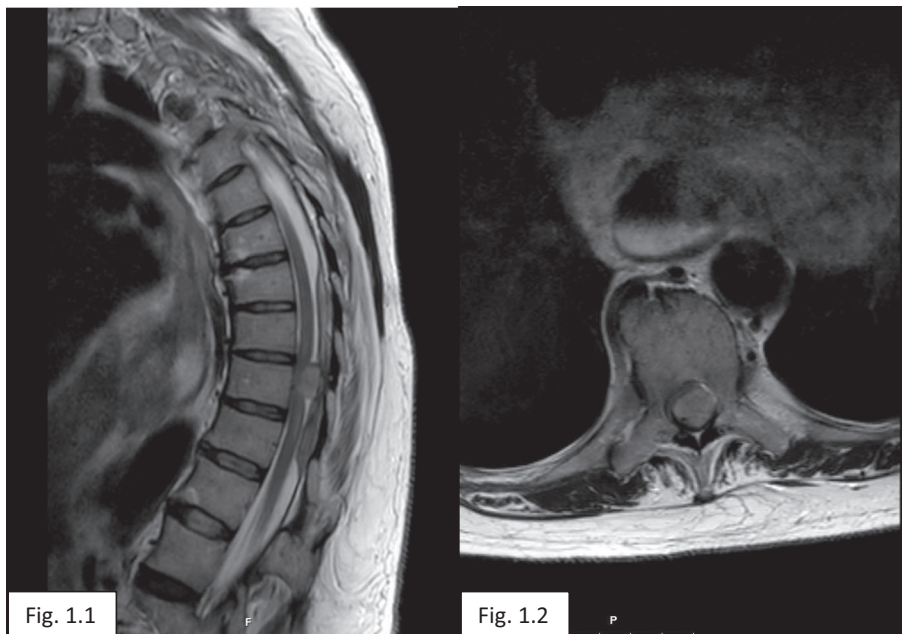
Preoperative spinal MRI, T2 sagittal section, hypointense intradural extramedullary lesion at D9-D10 level, note the subdural collection adjacent to the solid mass and extending two levels above and below the lesion. 1.2: Preoperative spinal MRI, T1c axial section, left posterior hyperintense lesion with homogeneous enhancement occupying the spinal canal with severe compression of the spinal cord.
